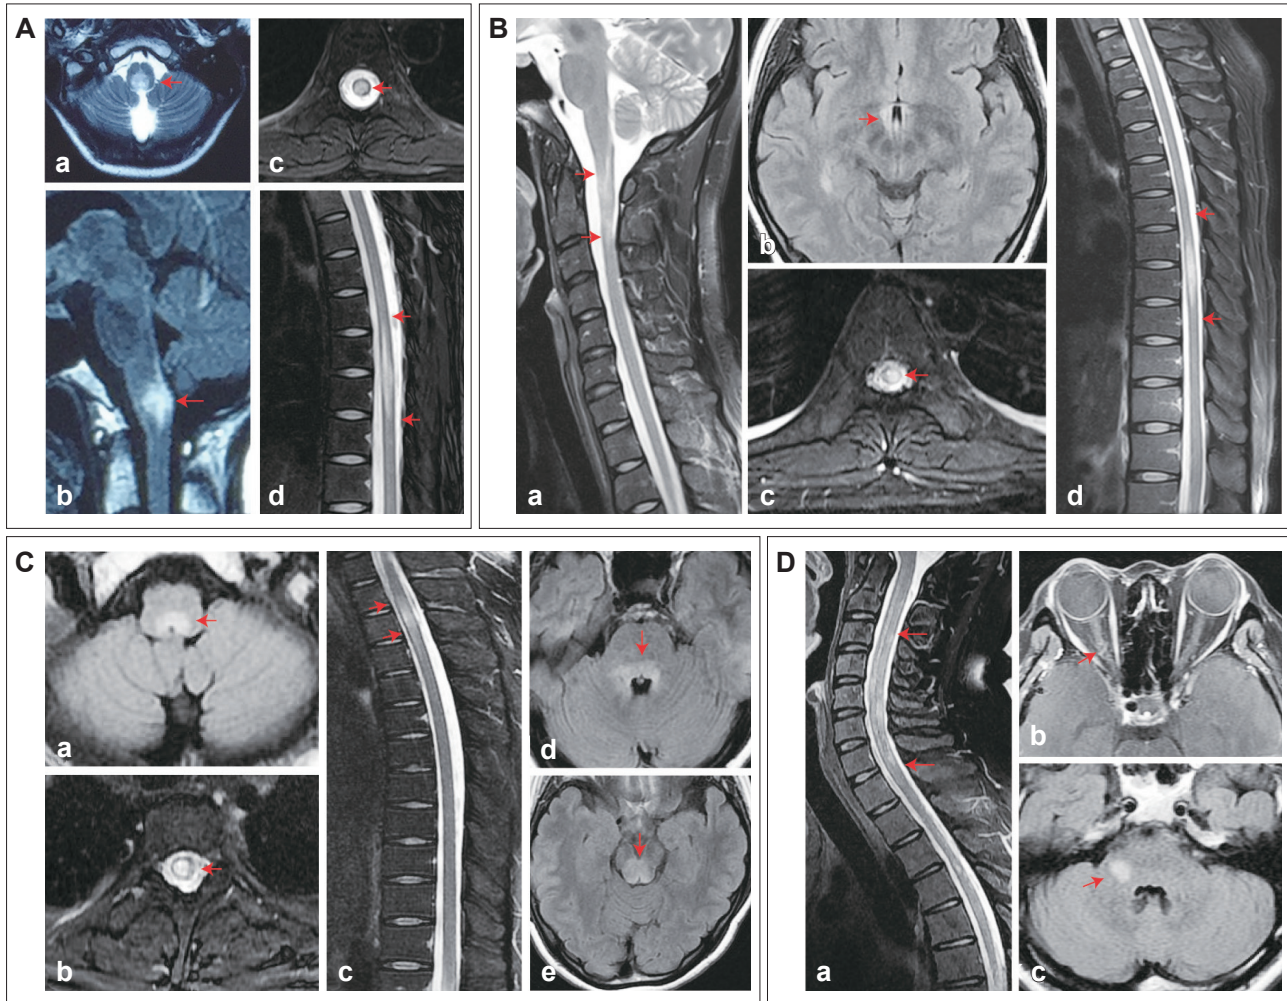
Representative MRI findings in this cohort. A: A 26-year-old female patient presented with intractable nausea, vomiting, and hiccups with a lesion in the area postrema of the dorsal medulla (a: axial view; b: sagittal view) in June 2018, and suffered from LETM (c: axial view; d: sagittal view) in March 2021. B: A 29-year-old female patient who was admitted to the hospital for simultaneous SSTM (a) and symptomatic narcolepsy associated with a lesion in the diencephalon (b) in January 2019 experienced LETM (c: axial view; d: sagittal view) in December 2020. C: Another 29-year-old female patient suffered from simultaneous area postrema syndrome (a) and SSTM (b: axial view; c: sagittal view) in September 2016, followed by an attack of acute brainstem syndrome with periependymal lesions around the pons (d) and dorsal midbrain (e) in January 2017. D: A 36-year-old male patient with suspected opticospinal MS based on simultaneous LETM (a) and optic neuritis (b) in November 2012, was finally diagnosed with MS after more than 5 years of follow-up. He experienced left facial numbness associated with a cerebellar peduncle lesion supportive of MS (c) in December 2017. LETM, longitudinally extensive transverse myelitis; MS, multiple sclerosis; SSTM, short-segment transverse myelitis.
